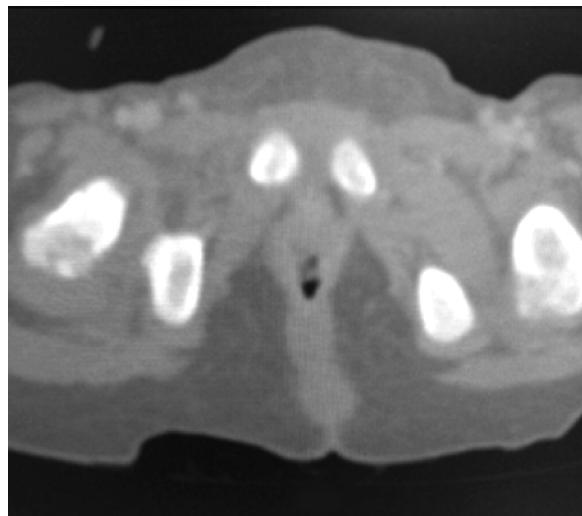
CT femur showing erosion in bilateral trochanteric areas.
